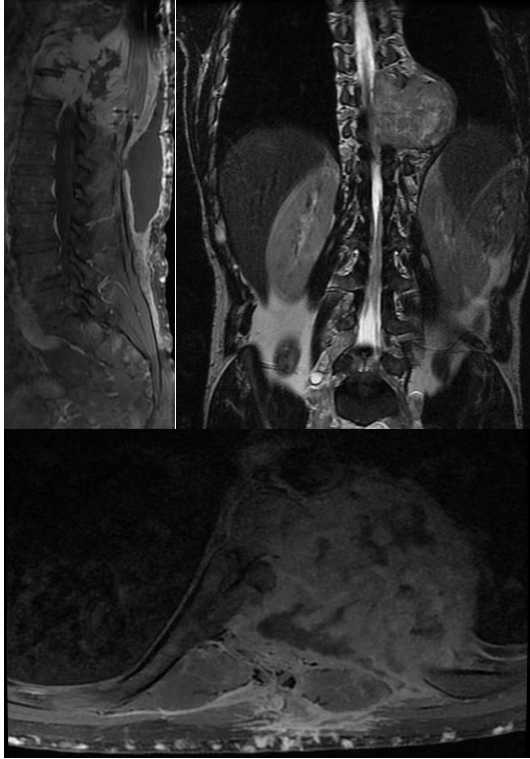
The medullary MRI revealed a formation with respect to D11-D12, in isotense T1, T2, heterogeneously enhanced after contrast with central necrosis, with a foraminal starting point measuring 85x78x66 mm, with external canal extension that measured 140x45 mm.
